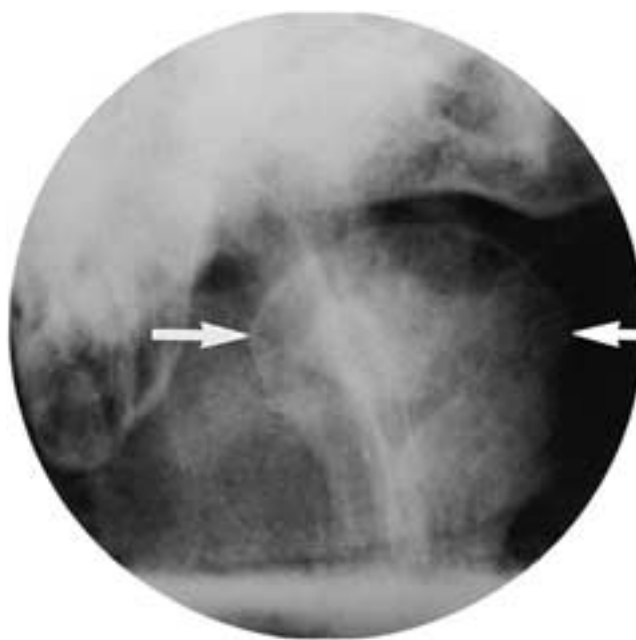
Transmaxillary radiograph of TMJ. The lateral and medial poles of the condyles are indicated by arrows.
